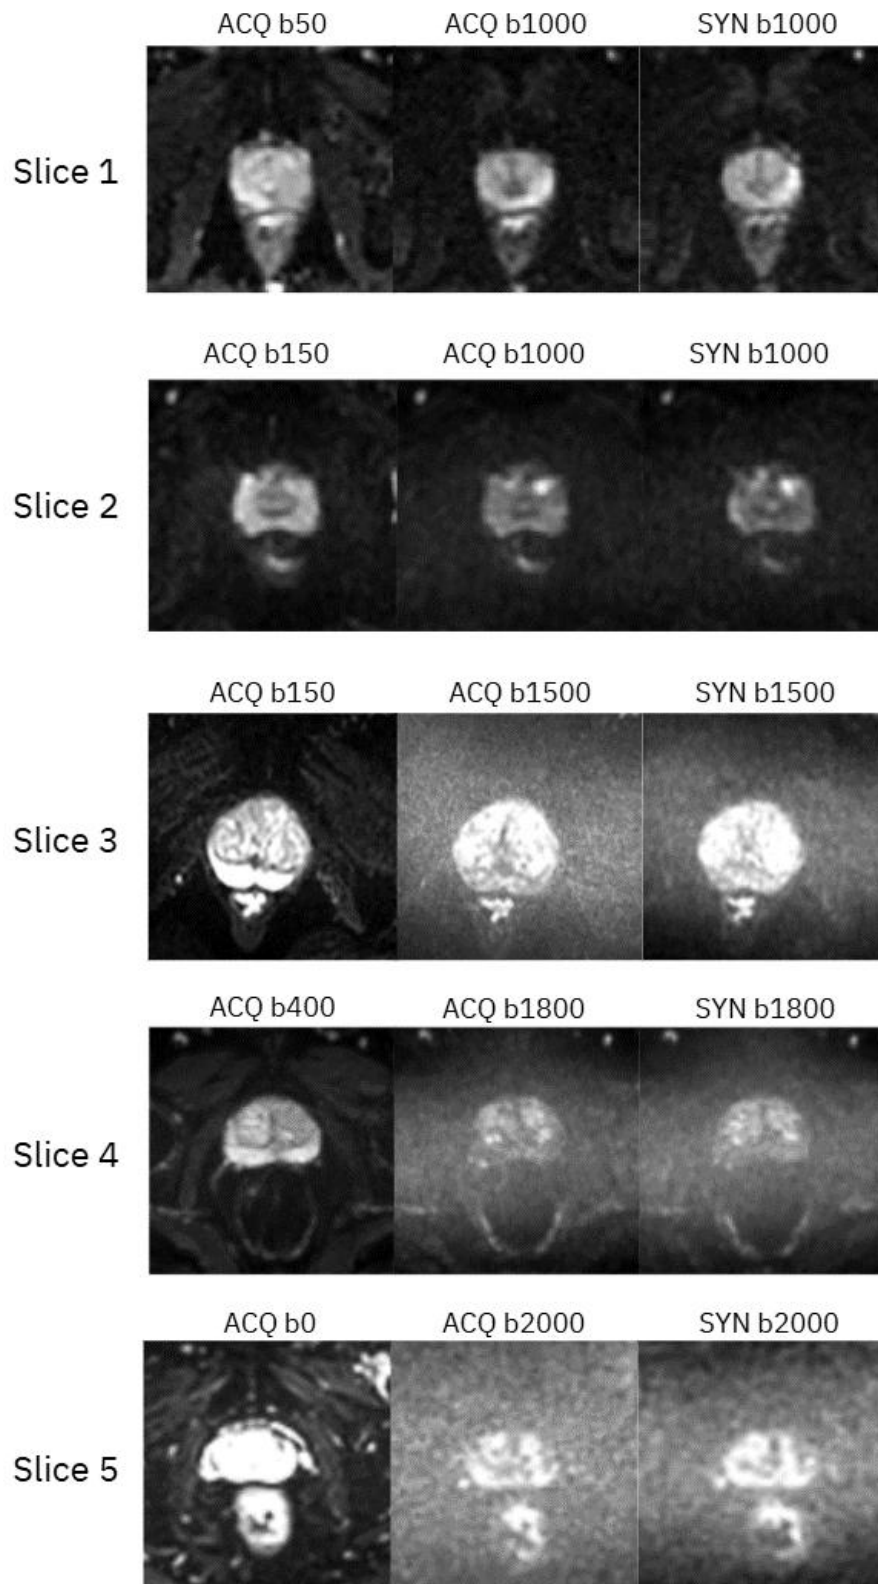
Comparative visualization of DWI across four randomly selected prostate study slices from the ProCancer-I database. Each row displays the acquired low b-value DWI (input), the acquired high b-value DWI (target), and the synthetic high b-value DWI generated by the optimized DDPM (SYN), showcasing the model's performance across varying b-value transformations.
